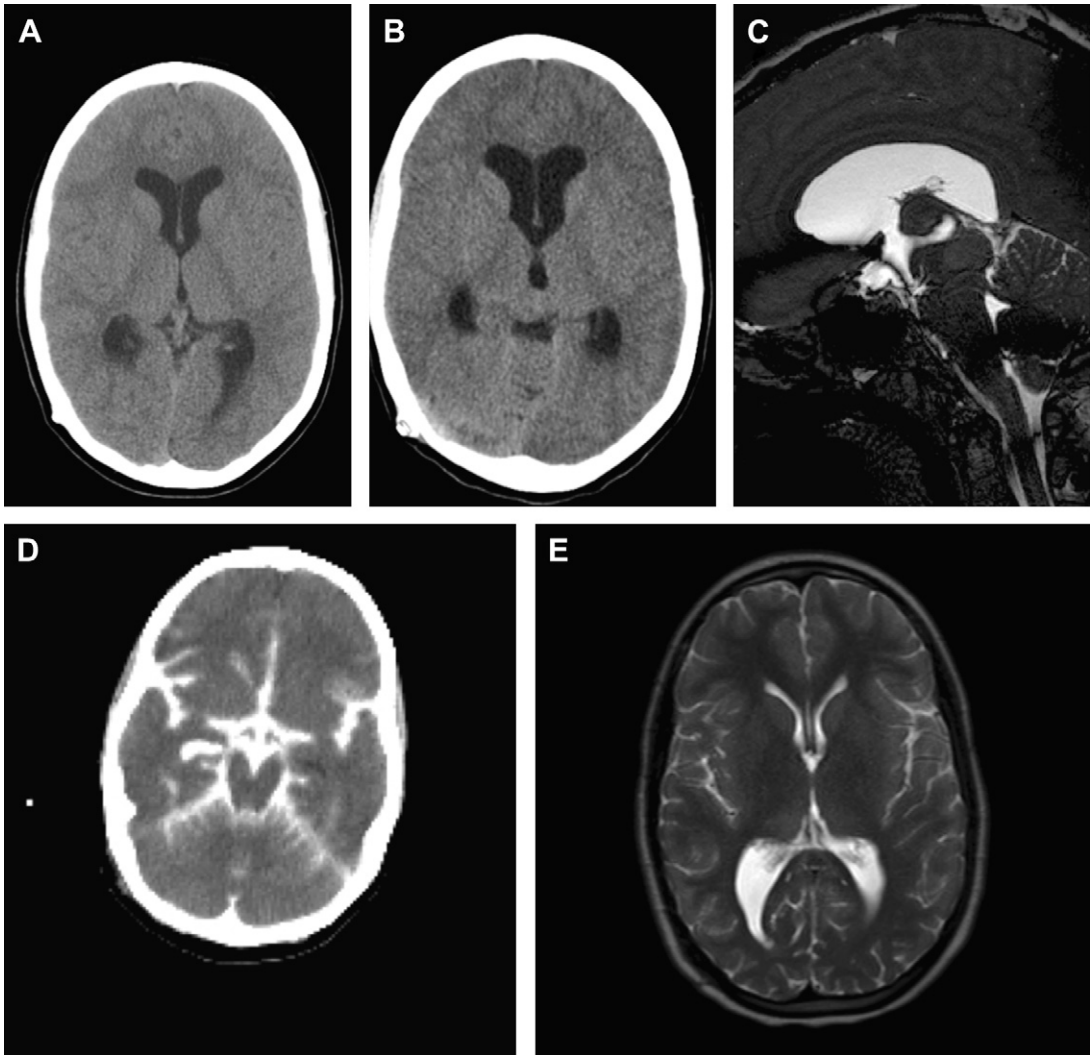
Case example: ETV with removal of malfunctioning ventriculoperitoneal shunt. This 12-year-old girl was shunted at birth for triventricular hydrocephalus. She presented 1 month after proximal revision with headache, nausea, vomiting, decreased level of consciousness, and bradycardia. Head CT on presentation after removal of 20 mL CSF from shunt reservoir (*B*) showed enlarged lateral and third ventricles compared with baseline scan (*A*). High-resolution sagittal MRI CISS sequence (*C*) showed evidence of obstruction at the level of the aqueduct, and suggested she would be a good candidate for ETV. After ETV, an external ventricular drain was placed and transduced ICPs were normal. Instillation of ventricular iodinated contrast showed communication of all CSF spaces (*D*). MRI scan obtained 3 months later (*E*), when she was feeling “better than baseline,” showed ventricles that were smaller than prior well baseline, suggesting partial obstruction or nonideal valve pressure on her original shunt.
